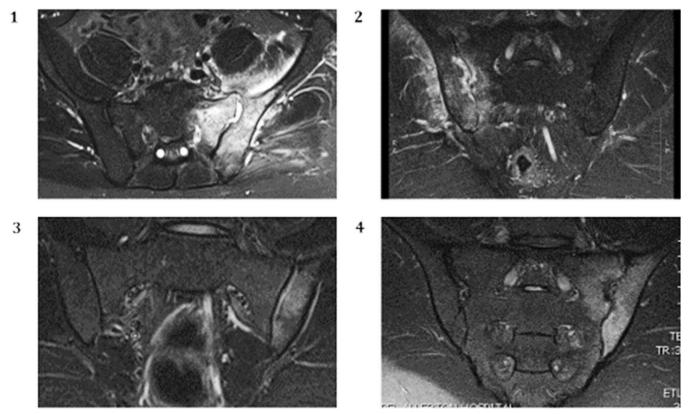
Coronal STIR MRI examination of the sacroiliac joints per case. Cases labeled by corresponding number. STIR: short-tau inversion recovery; MRI: magnetic resonance imaging.
